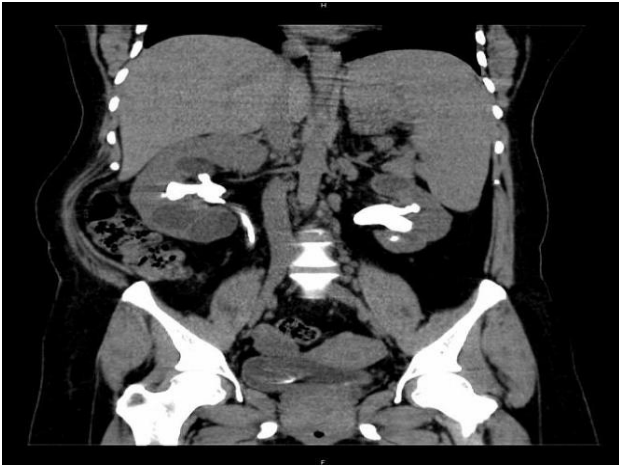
Coronal view of CT-KUB showing left renal calculus and right retained DJStent with stone formation in kidney.
